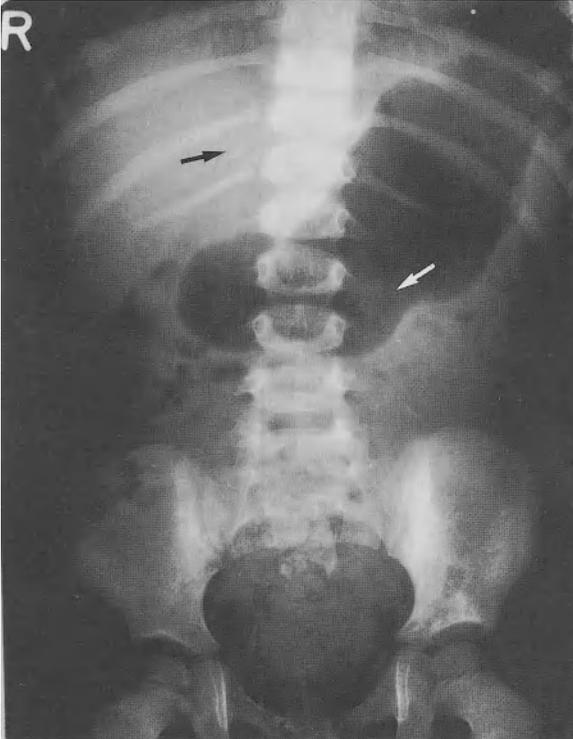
Case 2, preoperative plain abdominal radiograph. Typical stage IV neuroblastoma with clearly visible left and right paravertebral calcifications. Delayed primary operation because of progressive metastases (*arrows*)
